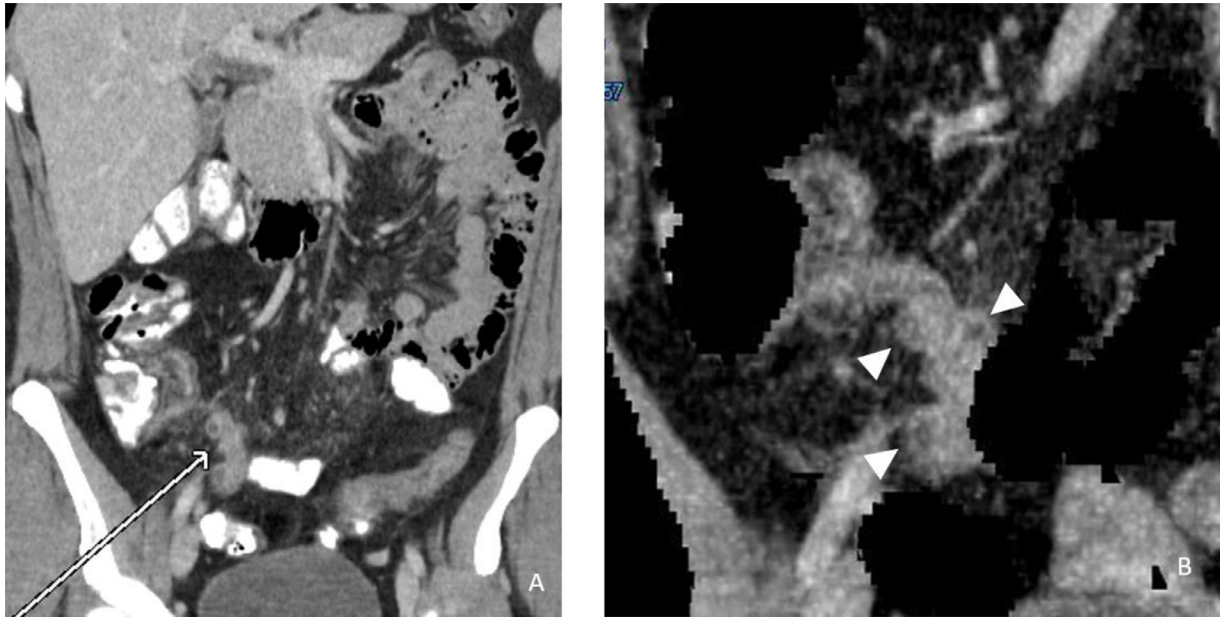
Coronal CT of the abdomen (A) showing outpouchings from a dilated, otherwise normal appendix (white arrow), without periappendiceal fat stranding or fluid collections. The corresponding magnified reconstructed image (B) showing the diverticula of the appendix (arrow heads) arising from the mesenteric and antimesenteric margins.
